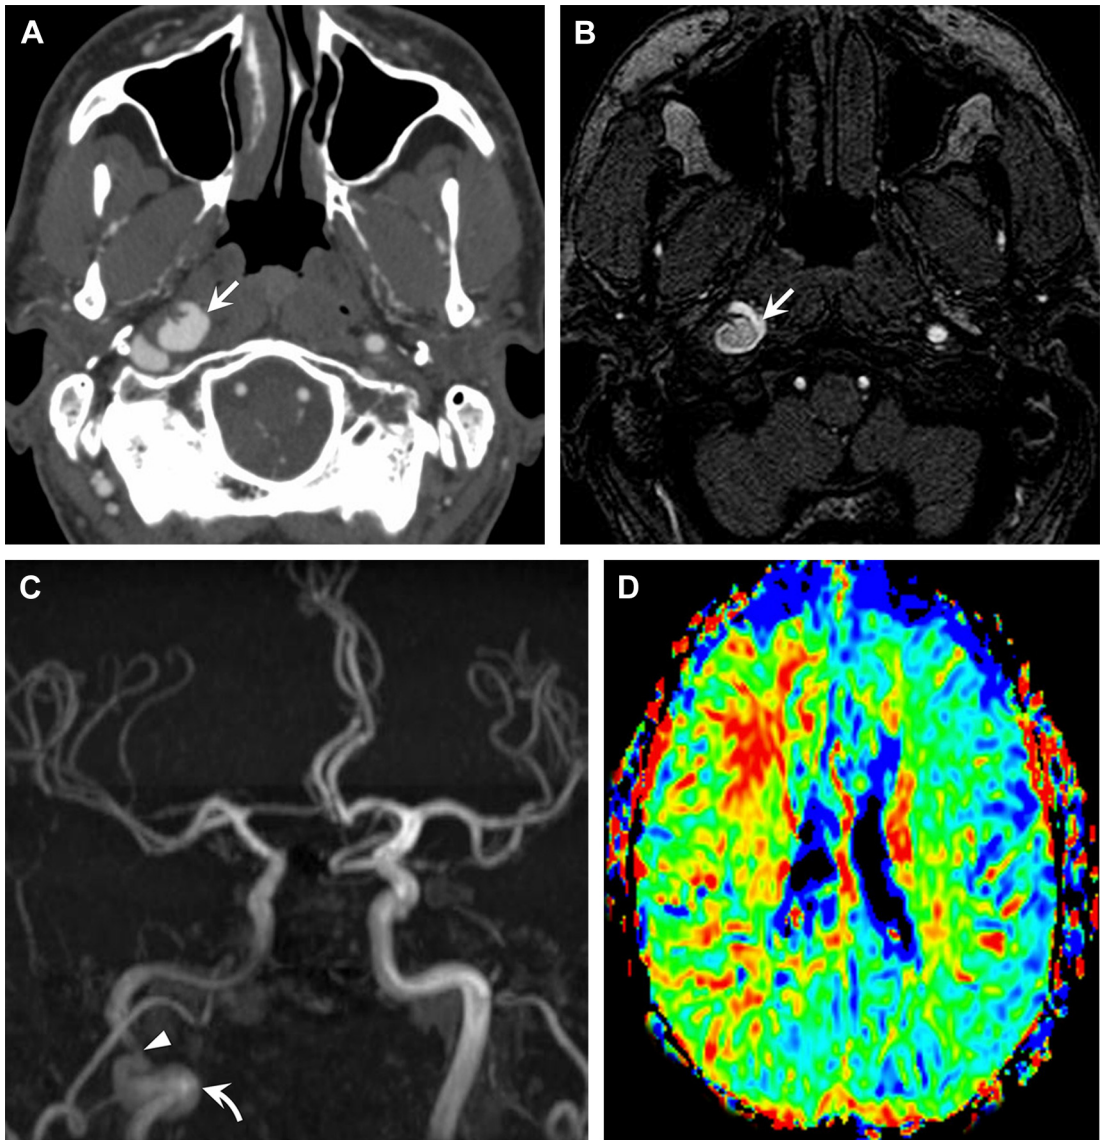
Right internal carotid dissection, pseudoaneurysm, and hemispheric perfusion defect. (A) Axial CTA and (B) 3D-TOF MRA images reveal an enlarged, irregular ICA lumen compatible with traumatic pseudoaneurysm (*arrow*). (C) MIP MRA image confirms the pseudoaneurysm (*curved arrow*) and narrowed true ICA lumen (*arrowhead*). (D) Perfusion images demonstrate a prolonged transit time in the right hemisphere, indicating a risk of subsequent infarct.
